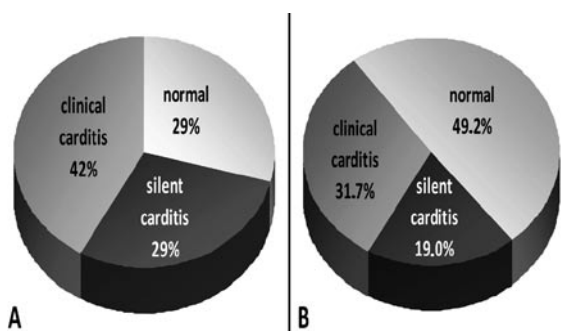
Clinical and echocardiographic findings of patients at the initial (A) and the last examination (B).
